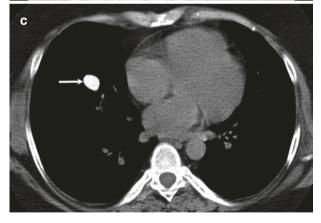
A 56-year-old woman with congenital bronchial atresia. (a) Frontal radiograph shows a tubular opacity (arrow) in right lower zone. (b, c) Axial CT images reveal hyperlucent lung surrounding a calcified bronchocele (arrow)
